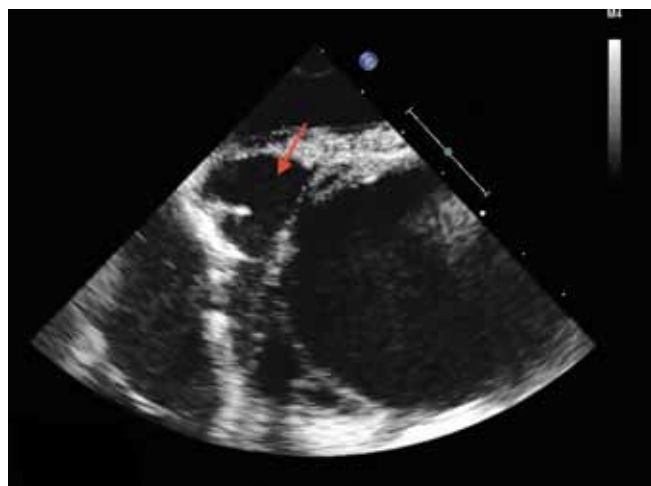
Transesophageal echocardiography, modified ME AV short axis (diastole, depth decreased). The LVOT pseudoaneurysm (red arrow) without evidence of communication to the aorta is seen in short axis at the supra-avalvular level
